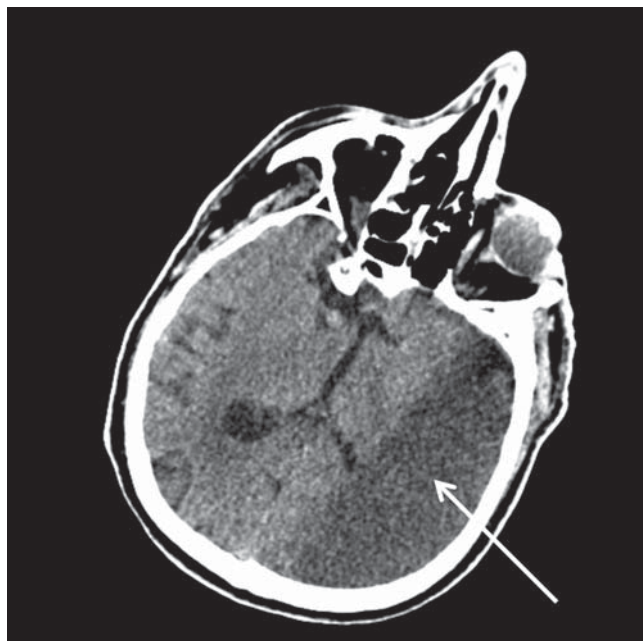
Computed tomography image of the brain showing left-sided ischemic stroke (arrow).
